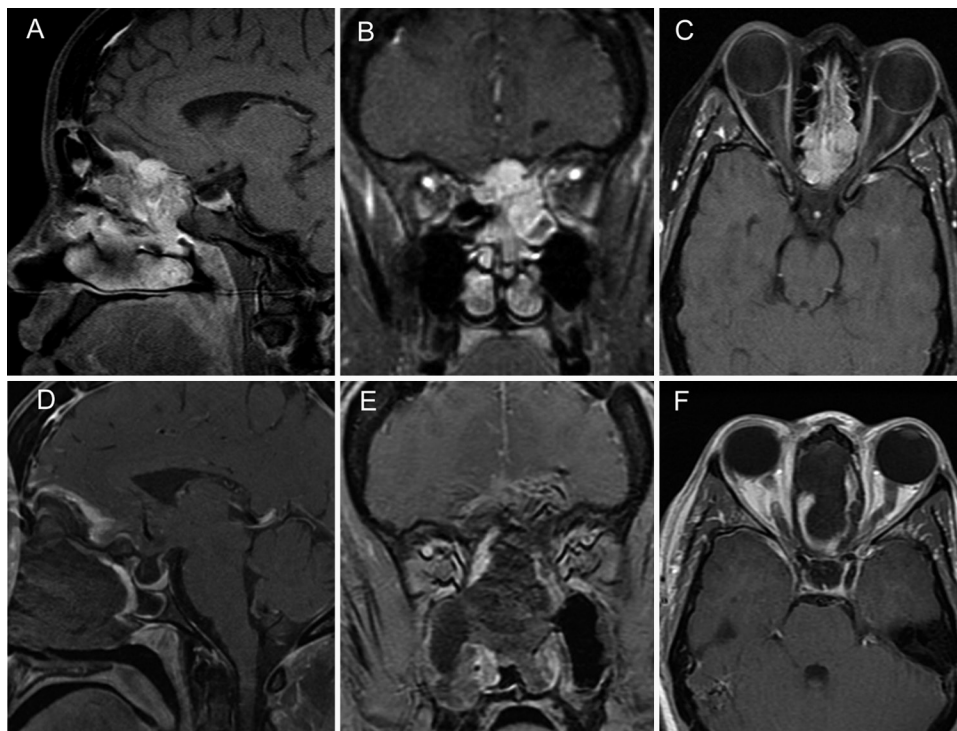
Case 2. A–C: Preoperative sagittal (A), coronal (B), and axial (C) T1-weighted Gd-enhanced MR images demonstrating a recurrent olfactory meningioma arising from the cribriform plate and planum sphenoidale with extension into the paranasal sinuses. D–F: Postoperative sagittal (D), coronal (E), and axial (F) T1-weighted Gd-enhanced MR images showing gross total resection of the tumor using an endoscopic endonasal approach. Enhancement at the ventral skull base represents the vascularized nasoseptal flap with some postoperative changes.
